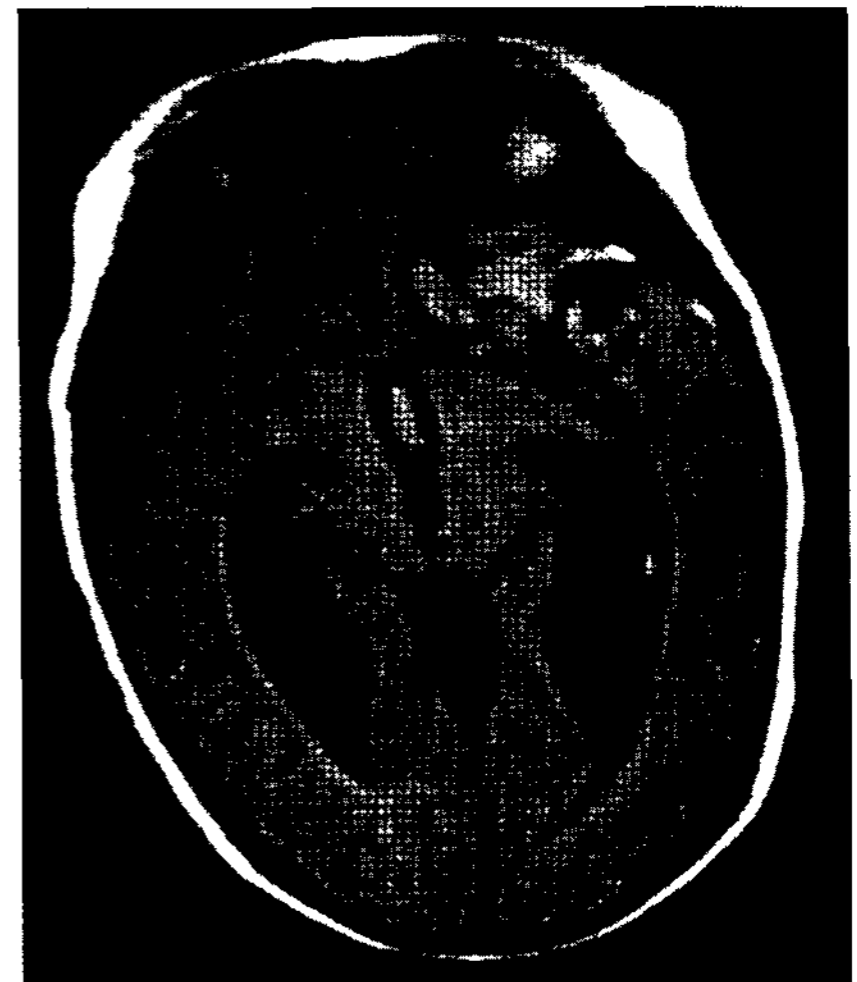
Preoperative magnetic resonance image (FLAIR) demonstrating a large hematoma in the left frontotemporal region associated with subarachnoid and intraventricular hemorrhage.
